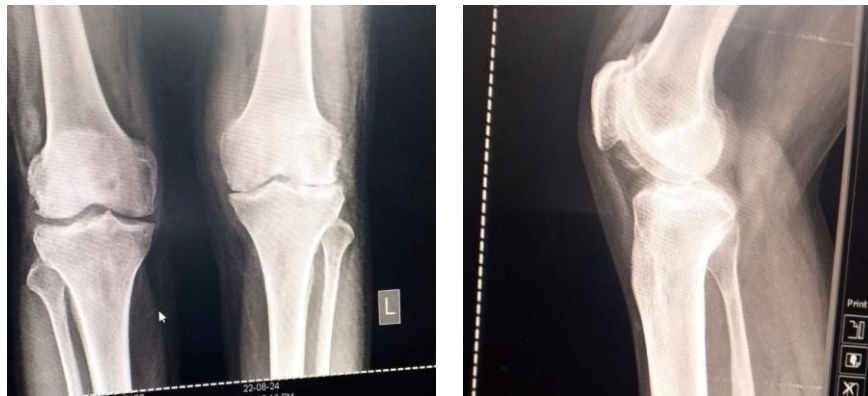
Knee Radiographs showing advanced osteoarthritis
